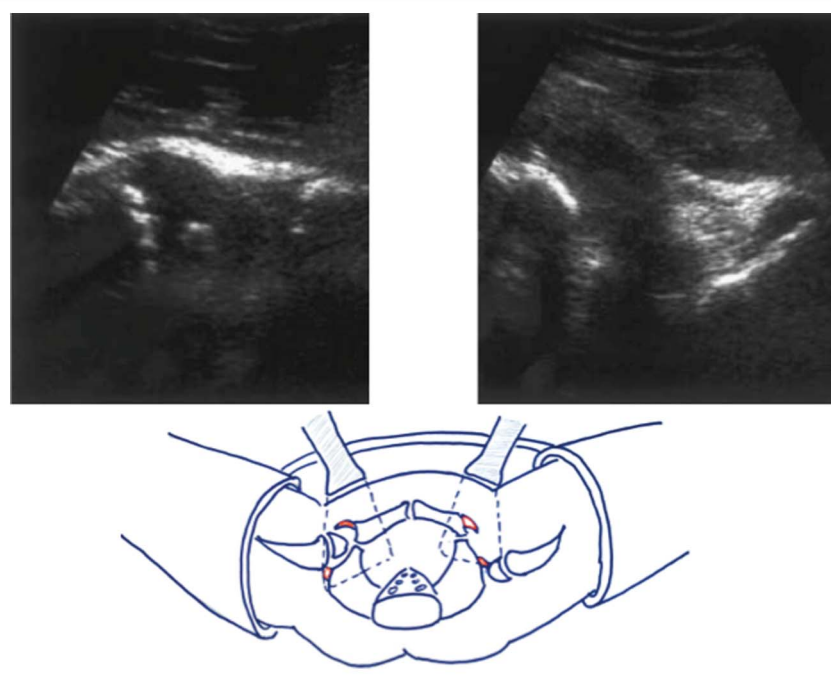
Figure demonstrating ultrasonography after closed reduction and spica casting with a persistently dislocated hip.
